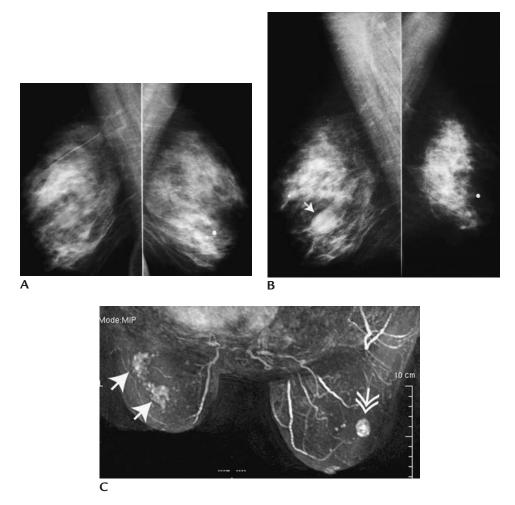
Recurrence, diffuse. (A) Mediolateral oblique views. Dense glandular tissue. Left breast is slightly smaller than right but there are no significant findings following a left lumpectomy and radiation therapy for invasive ductal carcinoma. Radio-opaque wire used to mark prior biopsy (benign) site on the right. (B) Mammogram several years following (A). The left breast has decreased in size and the overall density of the parenchyma is increased. An oval mass (*arrow*) is present in the right breast (fibroadenoma). (C) Magnetic resonance imaging, maximum intensity projection (MIP) image. Regional, irregular, stippled enhancement (*arrows*) laterally in the left breast. Diffuse recurrence, intermediate grade invasive ductal carcinoma with lobular features. Mass with heterogeneous enhancement (*double headed arrow*) laterally in the right breast corresponding to fibroadenoma.
